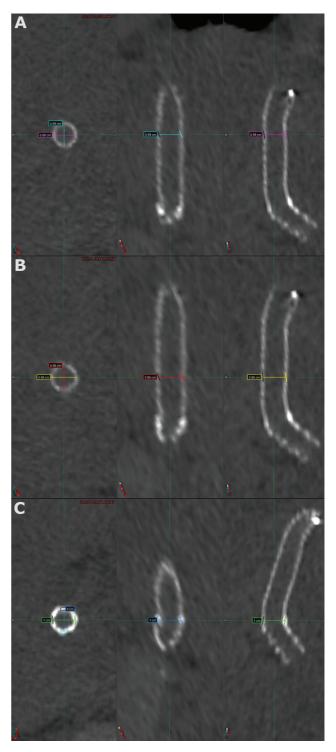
Measurement of transjugular intrahepatic portosystemic diameters on cross-sectional computed tomographic imaging (width: 1100, level: 300). (A) Cranial part of stent, (B) between cranial part and ring, and (C) at the ring.
